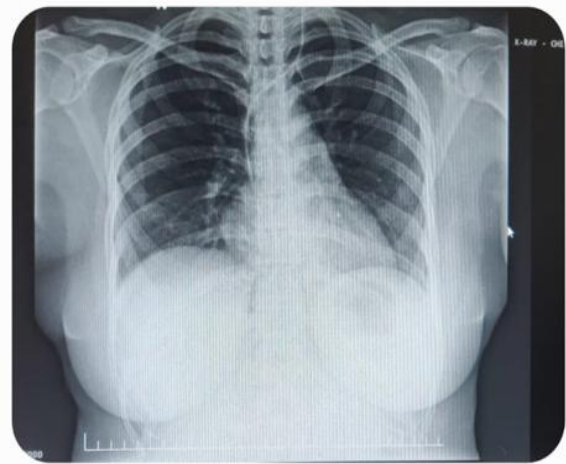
Follow up radiography showing resolution.
